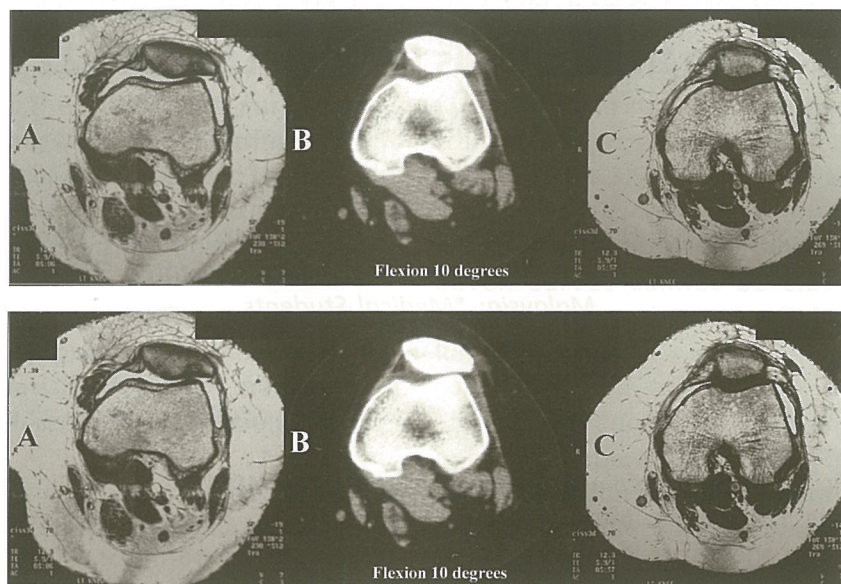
(A) Preoperative MRI showing effusion and thinning of articular cartilage of medial and lateral facets of the patella. (B) CT scan with the knee in 10° of flexion demonstrating patellar maltracking. (C) Postoperative MRI at 6 months showing good filling of the previous defect with repair tissue
